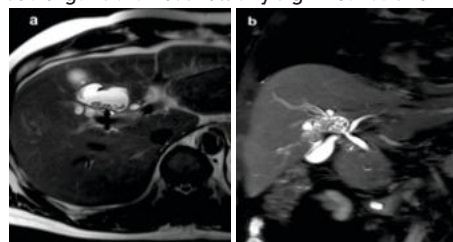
T2 Weighted Magnetic Resonance Images Showing a Lobulated Cystic Lesion in Segment IVB of Liver with Multiple Calculi Within.
